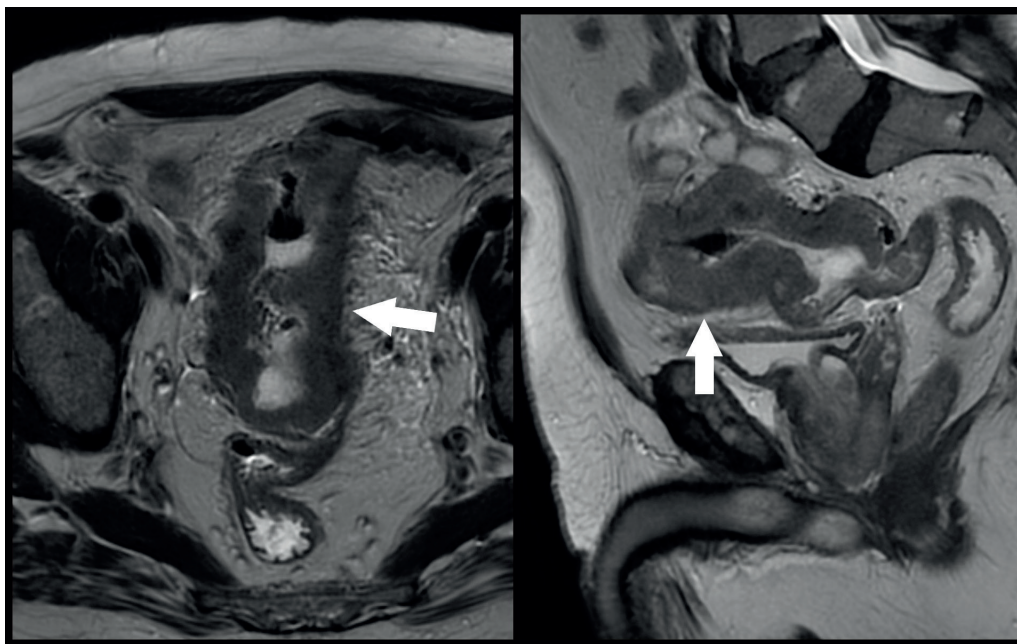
MRI of a tumor in the distal third of the sigmoid colon, up to 80 mm in length, with 4 mm of invasion into the mesocolon tissue (white arrows)
